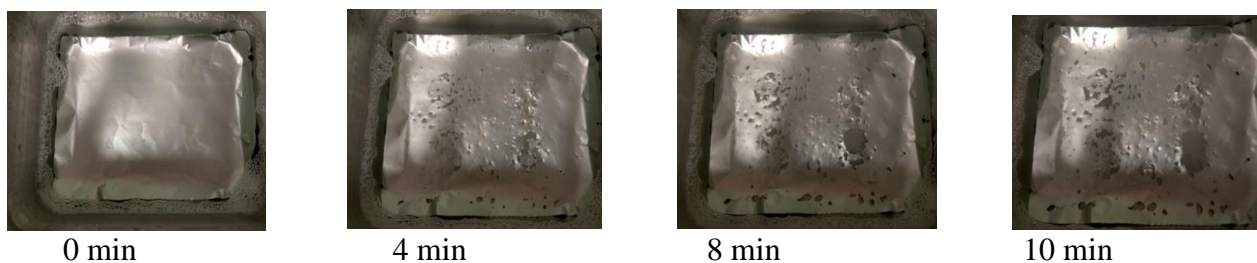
Foil test in ultrasonic water bath (VWR 250HT)
